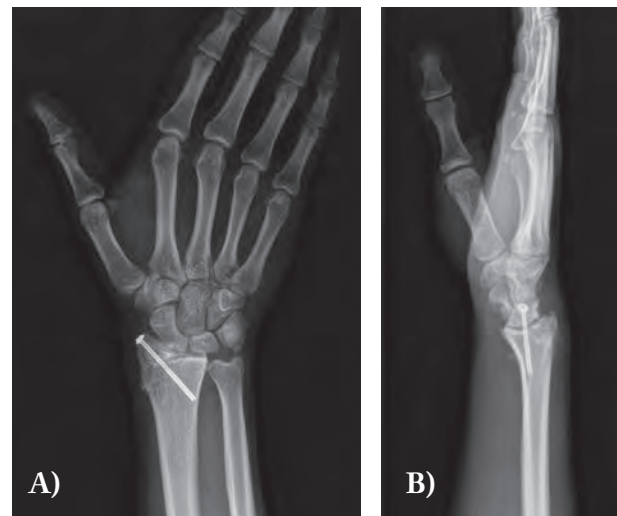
Preoperative CT study with physeal plate nonunion of distal radius; AP (A) and LL views (B)
